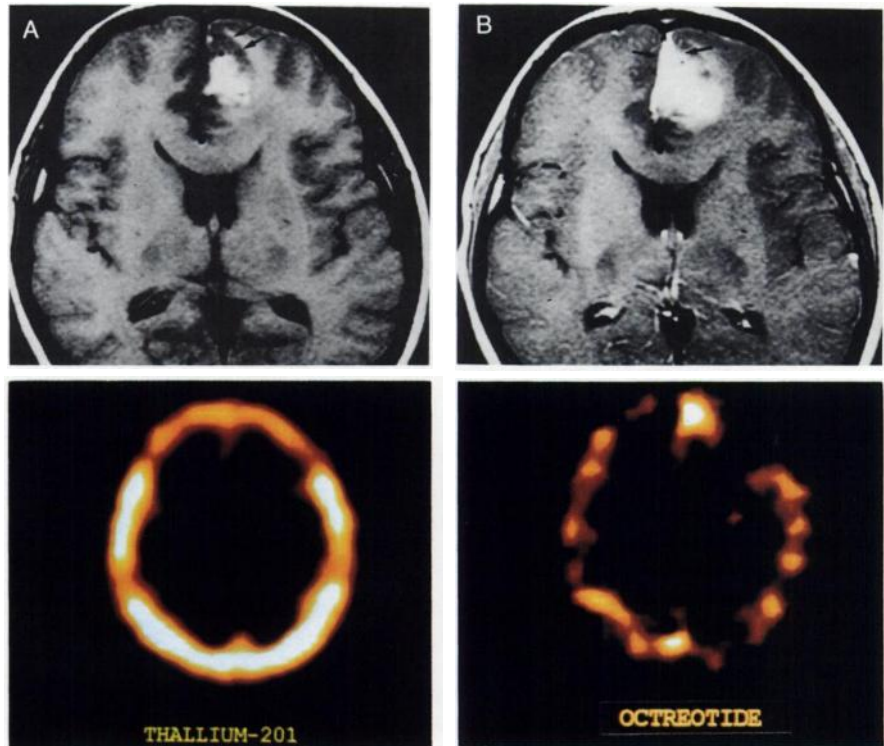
A 21-yr-old female with glioblastoma multiforme at the left frontal lobe. (A) Precontrast T1-weighted MRI shows increased signal intensity representing hemorrhagic necrosis at left frontal lobe in the vicinity of the anterior interhemispheric fissure. Surrounding low signal intensity of tumor tissue can be observed (arrows). (B) Gd-enhanced MRI depicts strong contrast enhancement along the periphery of the tumor (arrows). (C) Thallium-201 SPECT shows no radiotracer uptake within the tumor. (D) Indium-111-pentetreotide image demonstrates increased uptake along the periphery of the tumor margin, which is well matched with Gd-enhancement pattern on MRI.
